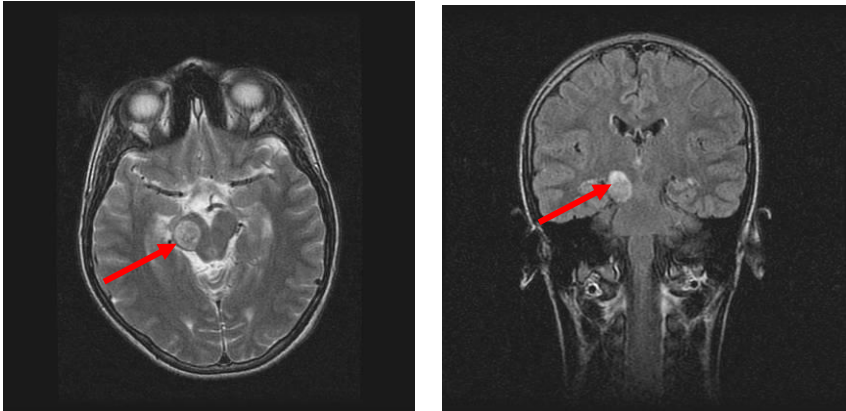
MRI examination of a case of diffuse brainstem glioma (personal collection of Prof. Dr. Stefan Ioan Florian)
